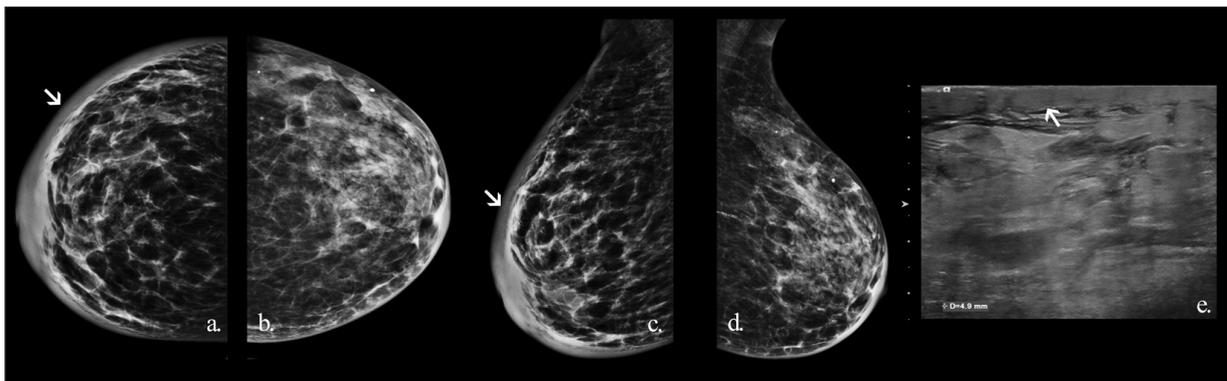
a) RCC, b) LCC, c) RMLO, d) LMLO mammography, e) Ultrasonography images show severe thickening in right breast skin, subcutaneous fatty tissue and breast parenchyma edema (arrow). RCC: Right cranio caudal; LCC: Left cranio caudal; RMLO: Right mediolateral oblique; LMLO: Left mediolateral oblique.
